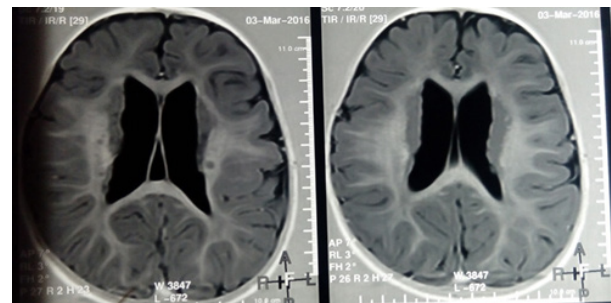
patient 1 CT findings suggestive of Cortical thickening in the bilateral fronto-parietal and occipito-temporal lobes with blunting of the sulci suggestive of polymicrogyria.*
